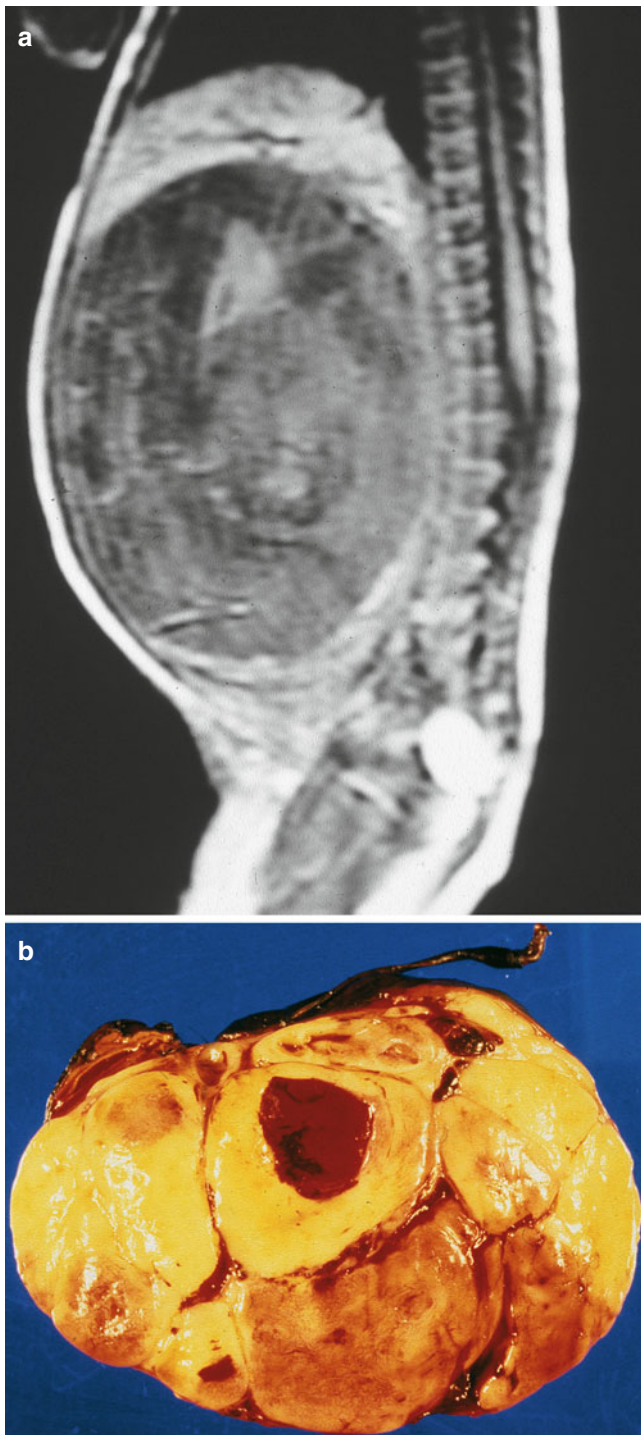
(a) Sagittal views of an MRI scan of a newborn infant with a massive renal tumor. (b) Cut surface of the tumor shows the classic appearance of rubbery tissue without necrosis consistent with a mesoblastic nephroma
